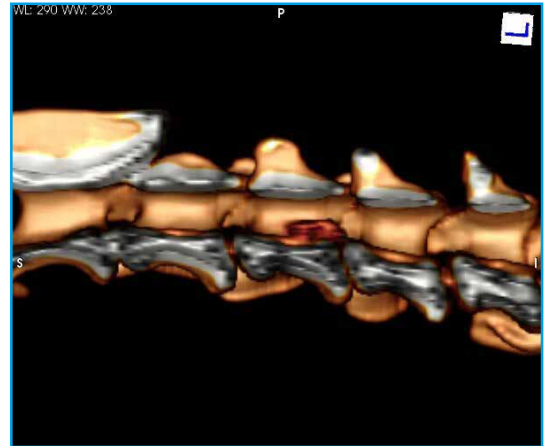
CT 3D reconstruction of a cervical disc extrusion.
